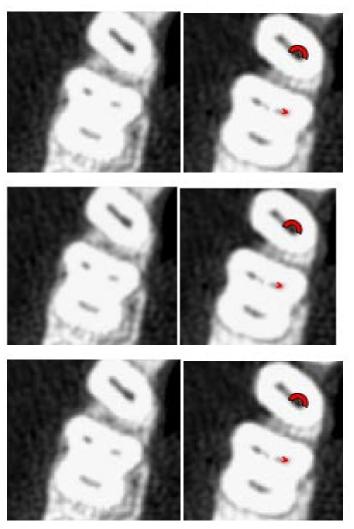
CBCT scan images before (left column) and after (right column) instrumentation. Red marks indicate canal transportation
